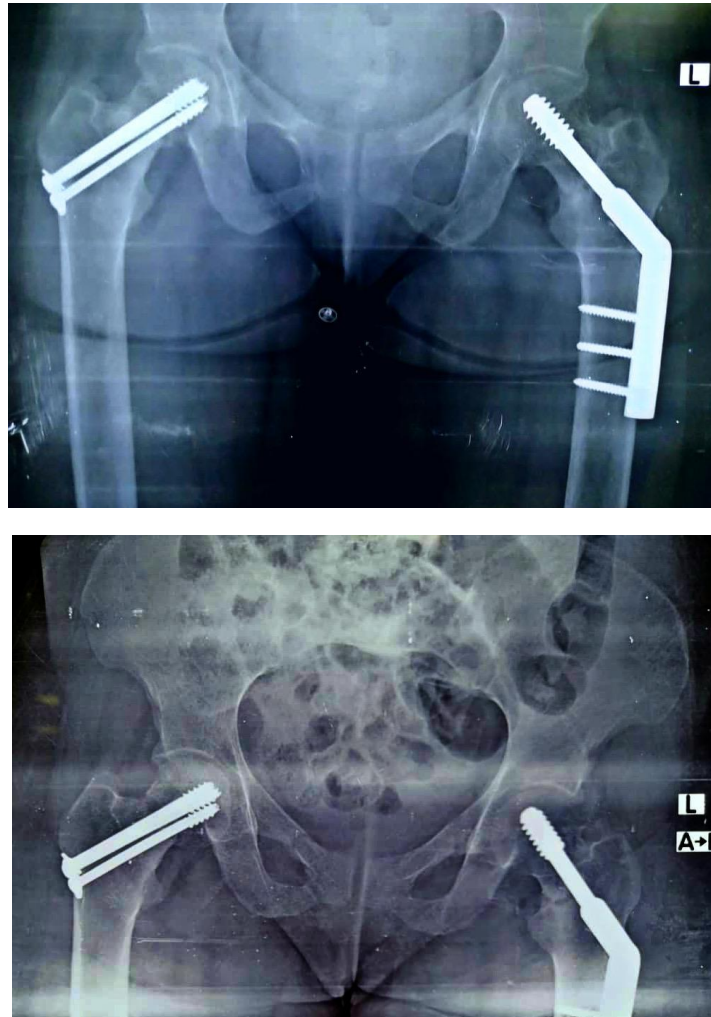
(B): Intraoperative radiograph showing open reduction and internal fixation on her left hip via Dynamic Hip Screw (DHS)
